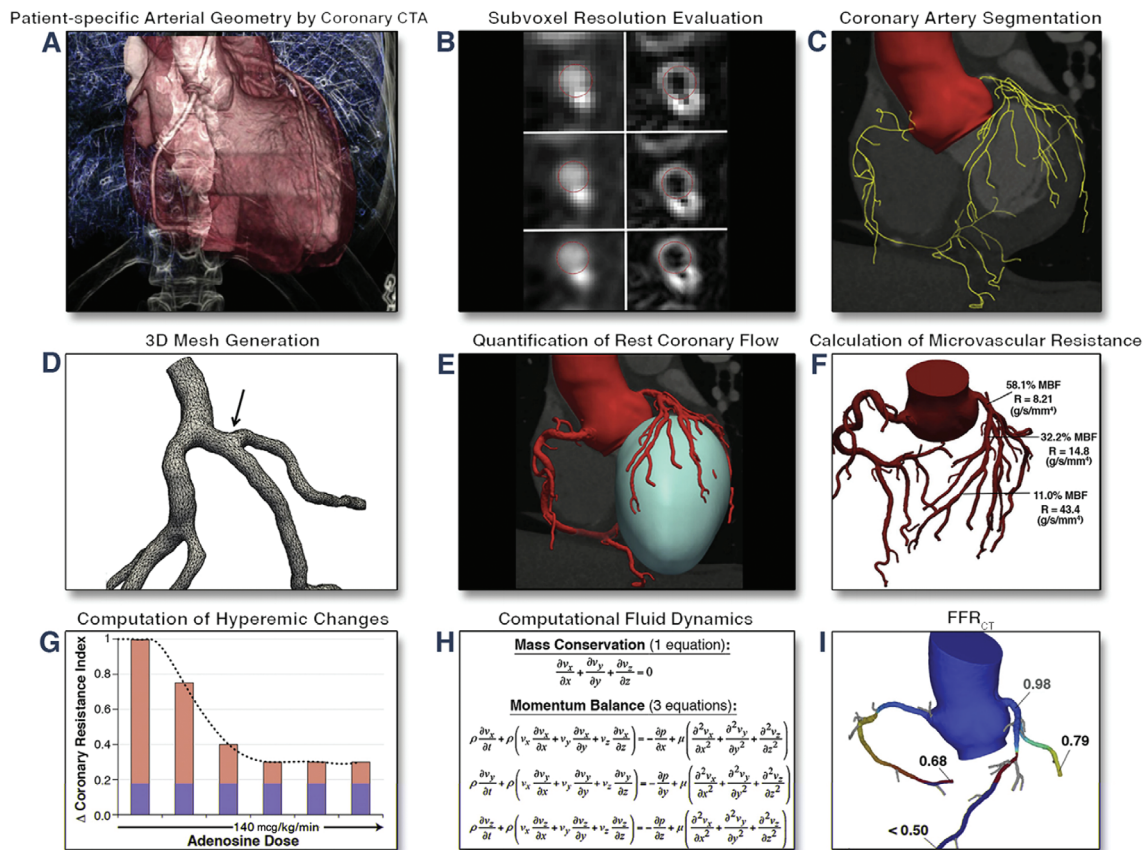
Step-by-Step Method for the Calculation of Fractional Flow Reserve Measured by Coronary Computed Tomography Angiography (FFR_{CT}).
